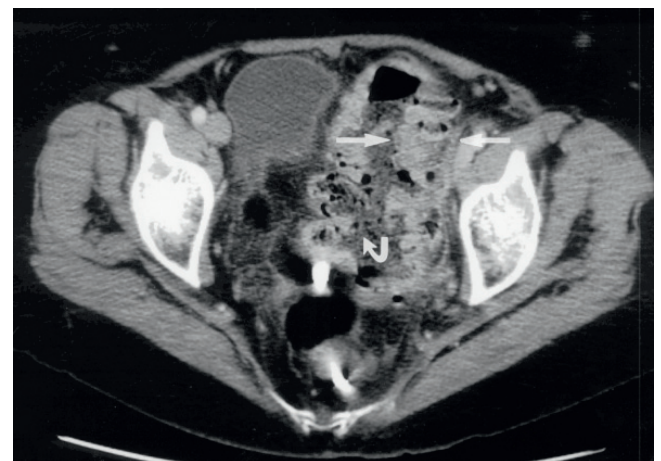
Computed tomographic scan shows marked thickening of the sigmoid wall (arrows) in a patient with diverticular disease who presented with symptoms of intractable constipation. No contrast is present in the lumen (curved arrow).
